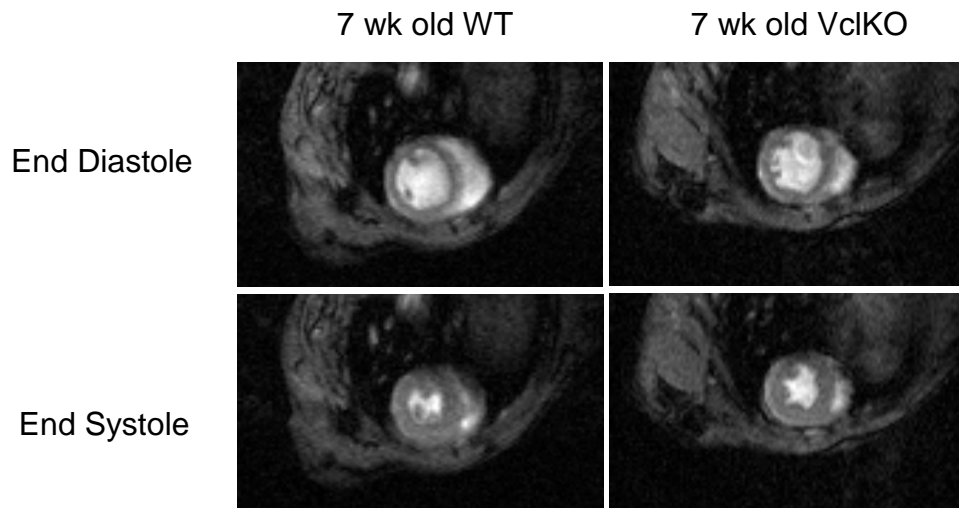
MR images of 7 week old WT and VclKO hearts.
